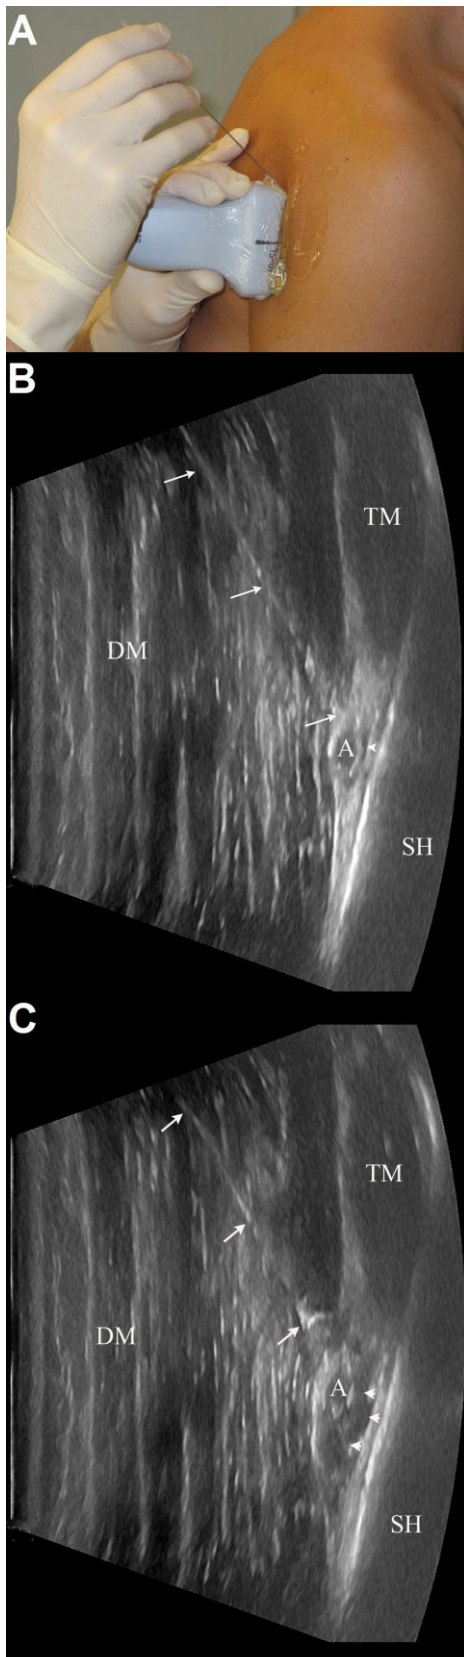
Ultrasound-guided axillary nerve block. (A) Patient and transducer position. Lateral view of the shoulder region demonstrating in-plane needle insertion with the transducer parallel to the longitudinal axis of the humerus. (B) Ultrasonographic image oriented as in (A), showing the needle in-plane with the needle tip just cranial to the posterior circumflex humeral artery (PCHA). Beginning of local anaesthetic spread is observed around the PCHA (0.5–1 ml). (C) Ultrasonographic image oriented as in (A), showing local anaesthetic spread (10 ml) around the PCHA. DM, deltoid muscle; TM, teres minor muscle; SH, humeral shaft; A, artery (PCHA); large arrows, needle (in-plane); small arrows, local anaesthetic.
